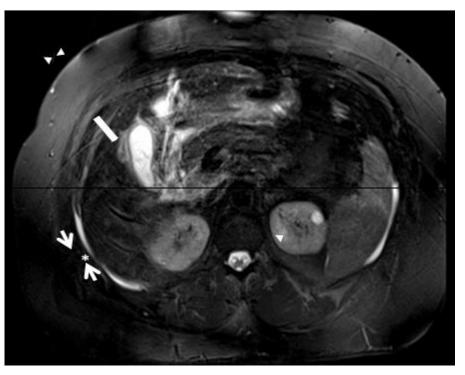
MRI SSFP image showing pericholecystic fluid collection
